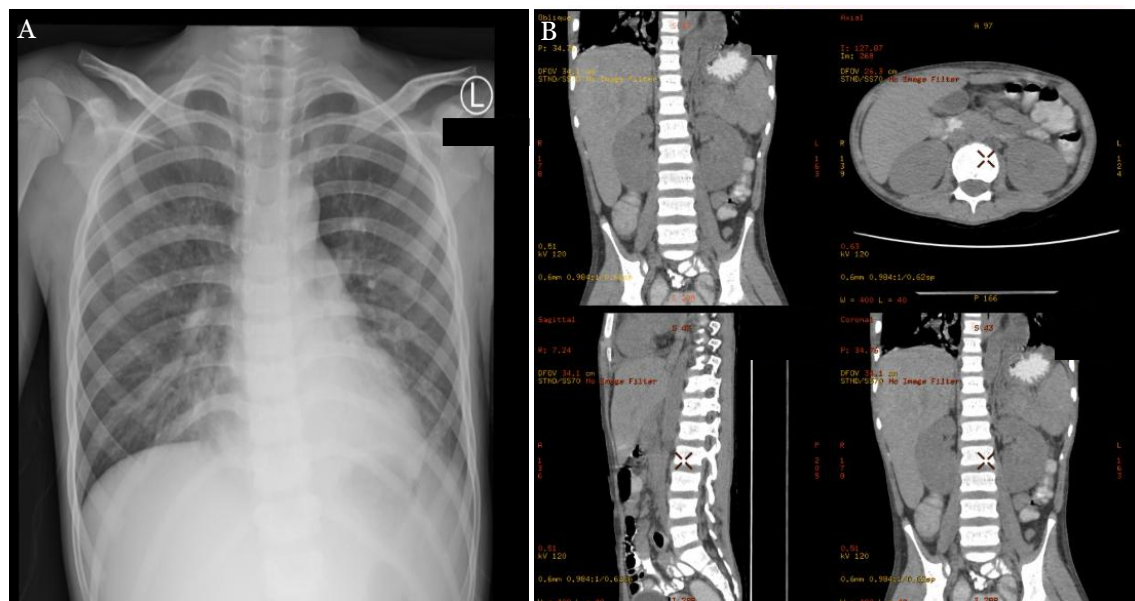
Imaging examination revealed cardiopulmonary and abdominal abnormalities. (A) Chest X-ray demonstrates cardiomegaly with pulmonary congestion, raising suspicion of pneumonia. (B) Non-contrast upper and lower abdominal CT scan shows grade 1 hydronephrosis with minimal pleural effusion.
